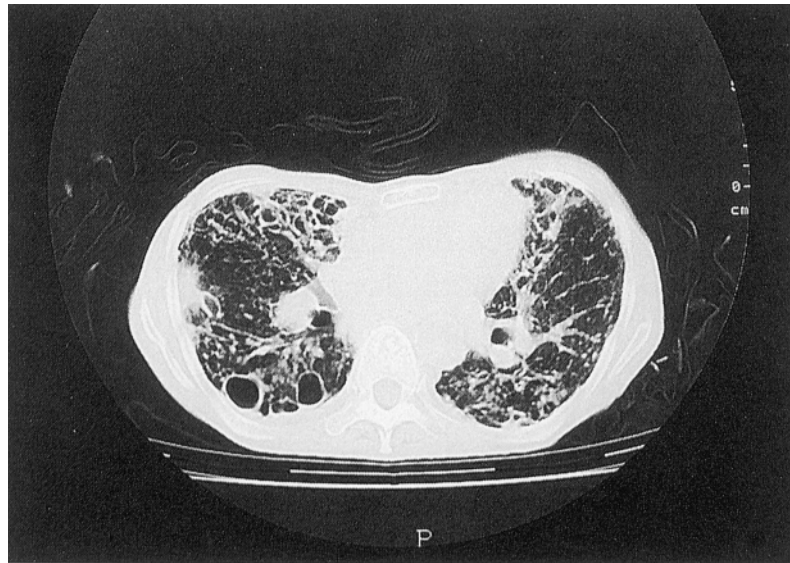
Computed tomography of the chest taken after the patient became to a steady state. Fig. shows bronchiectasis in both lungs with bullae and fibrotic changes.
